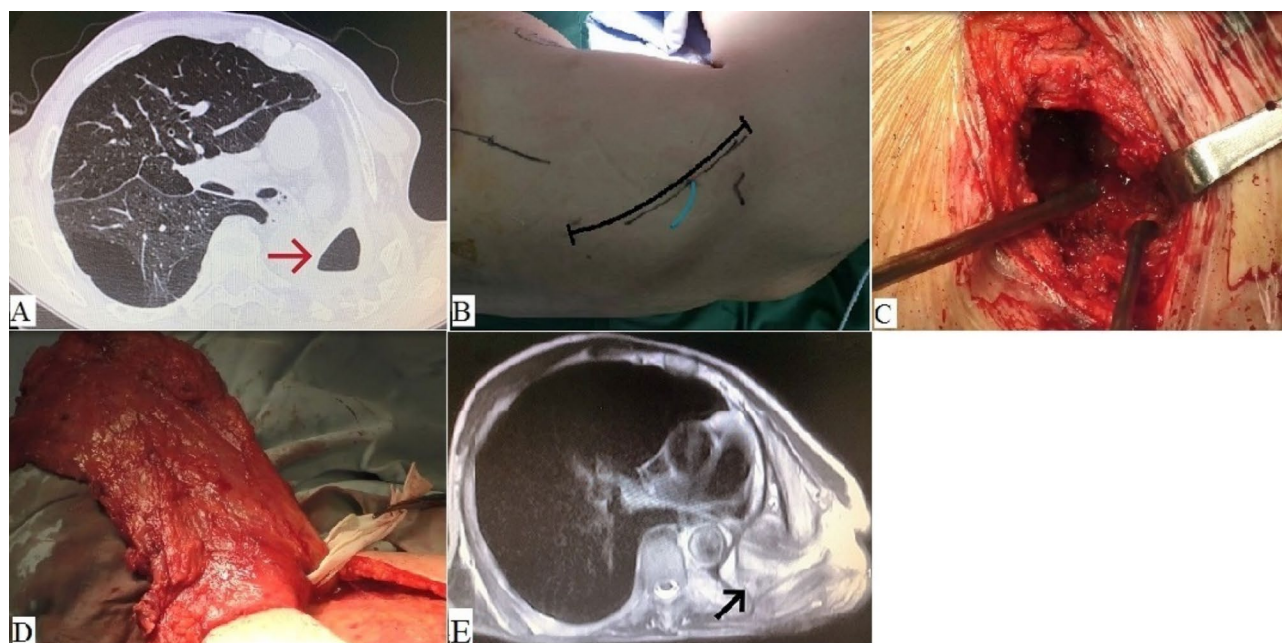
Clinical images on application of pedicled muscle flap. (A) A preoperative chest CT showed an empyema cavity containing pleural effusion in the left thorax; (B) Appearance and incision design of the chest wall before operation; (C) Appearance of abscess cavity after debridement; (D) Harvesting of the pedicled latissimus dorsi and serratus anterior muscle flap; (E) Postoperative MRI showed that the pedicled muscle flap completely filled the abscess cavity (black arrow)
